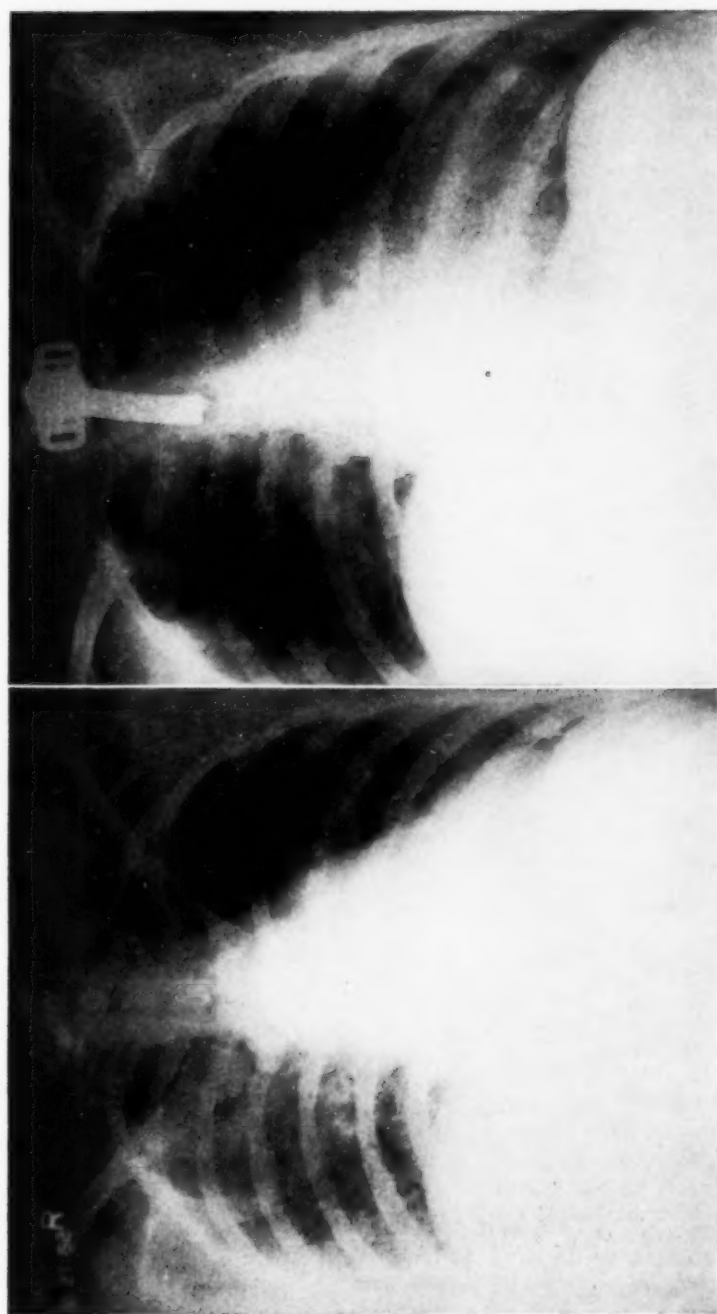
A. X-ray on day of aspiration of vomitus. Shows infiltration throughout the entire right and the left central lung fields. B. X-ray 24 hours after initiation of exsufflation reveals clearing of the exudative infiltration.
